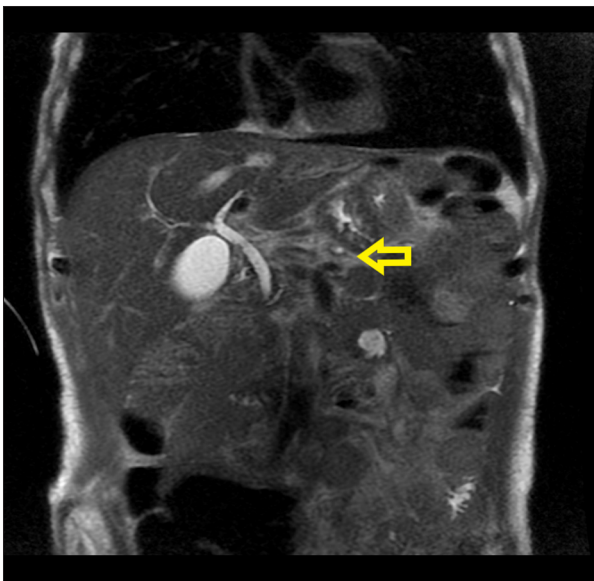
Magnetic resonance image of liver, showing changes suggestive of chronic pancreatitis (yellow arrow).
